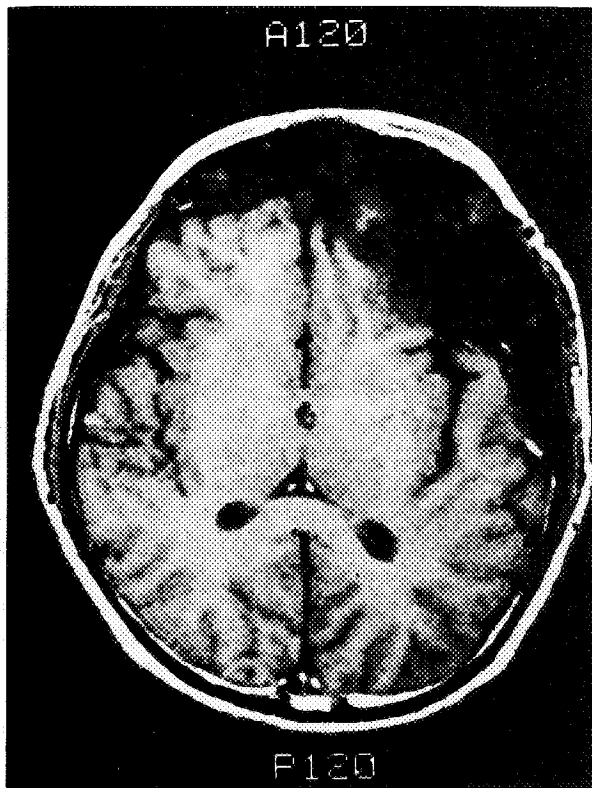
T1-weighted image of Patient 1. Fibrous dysplastic bone is identified as a low signal intensity area with sharply bounded border.
